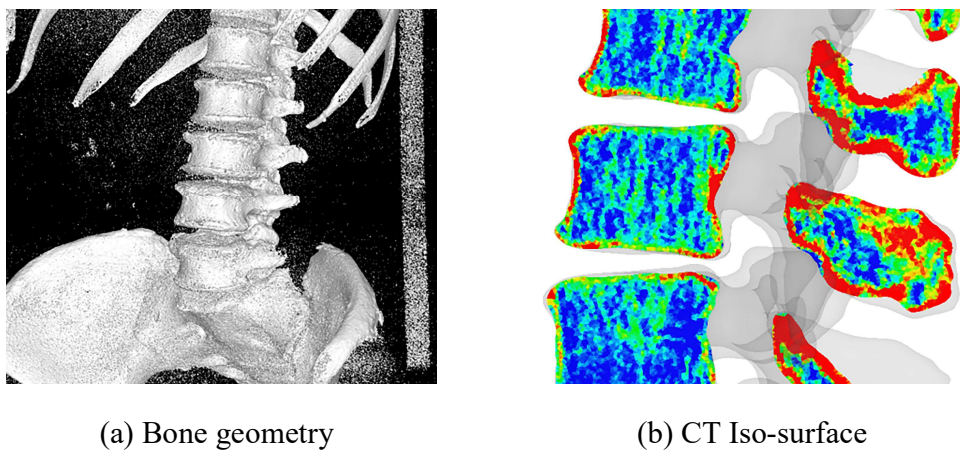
Bone geometry and corresponding CT Iso-surface extracted by MF.
